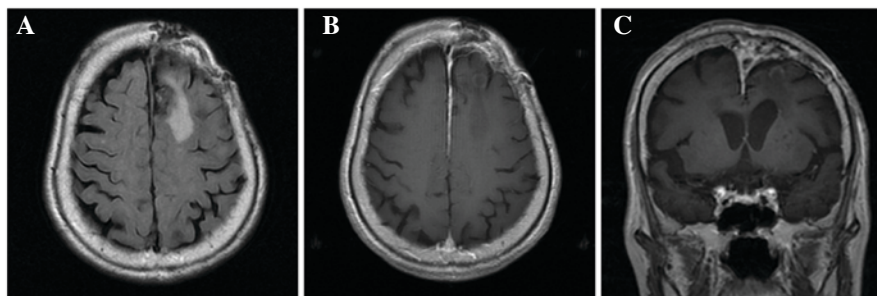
Follow-up magnetic resonance imaging performed 1 year after surgery. (A) Axial view of fluid-attenuated inversion recovery images, (B) axial and (C) coronal views of a contrast-enhanced T1-weighted images. No tumor recurrence was identified.
